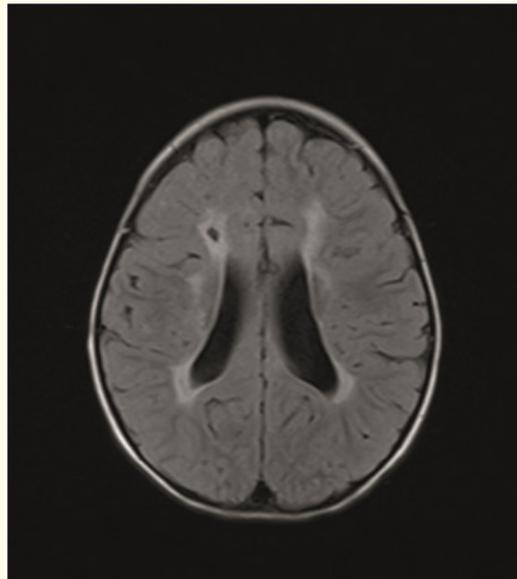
MRI of the brain. Patient S., 8 months old. Atrophic changes in the frontal lobes of the cerebral hemisphere.
